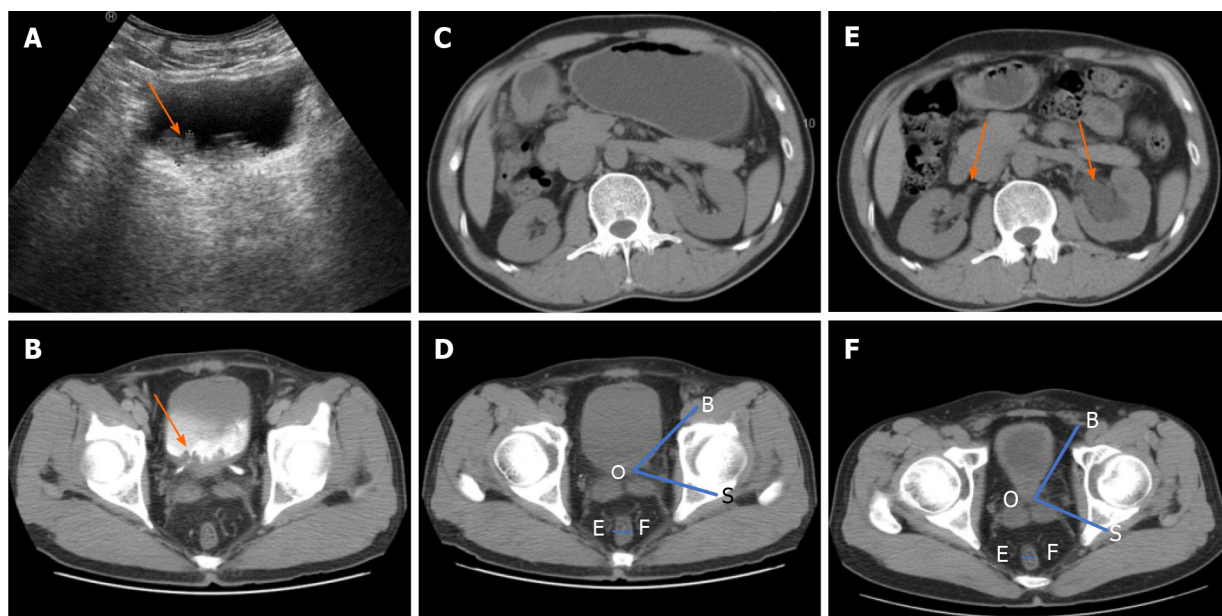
Imaging findings of cystitis glandularis with pelvic lipomatosis. A: Ultrasound examination showed that the mass was located in the triangular region of the bladder, with a burr-like protrusion and irregular thickened wall of the triangular region of the bladder; B: On first admission, computed tomography (CT) of the urinary system suggested thickening of the bladder wall, mainly on the posterior wall and the triangle area, and the mastoid process was observed inside the cavity. Mild to moderate continuous enhancement was noted in the delayed phase; C: Urinary CT scan for the first time revealed no hydronephrosis in the renal pelvis and ureter; D: Angle between the bladder and seminal vesicle (ABS) in the axial cross-section (\angle BOS) and the axial cross-sectional diameter of the rectum (EF) in CT at the first visit. The bladder morphology was elliptical; E: CT was reviewed 3 mo after the second transurethral resection of bladder tumour (TUR-BT). The pelvises, calyces, and ureters on both sides dilated, especially on the left side; F: CT review 3 mo after the second TUR-BT: ABS in the axial cross-section (\angle BOS) became larger and the axial cross-sectional diameter of the rectum (EF) became smaller. The adipose density around the bladder and around the rectum increased, the rectum was compressed, and the bladder shape was inversely pear-shaped.
